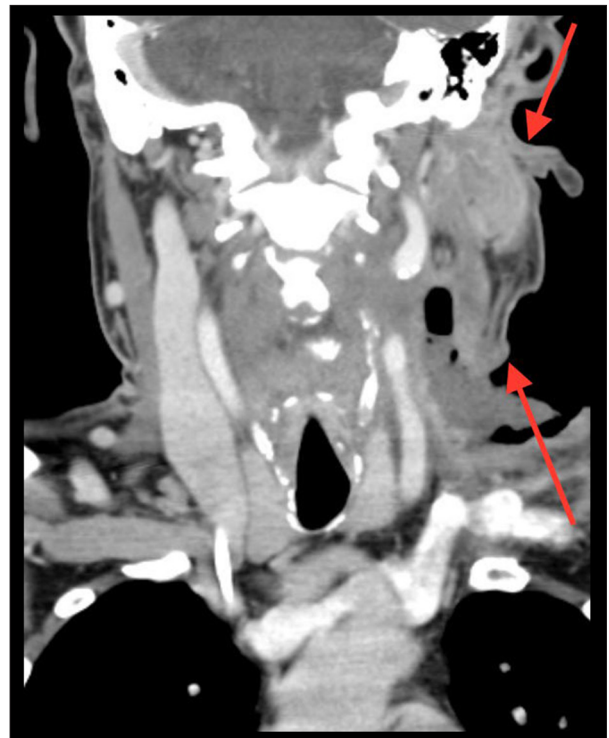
Computed tomography image demonstrating remission after immunotherapy/radiation. Arrows denoting remaining tumor.
